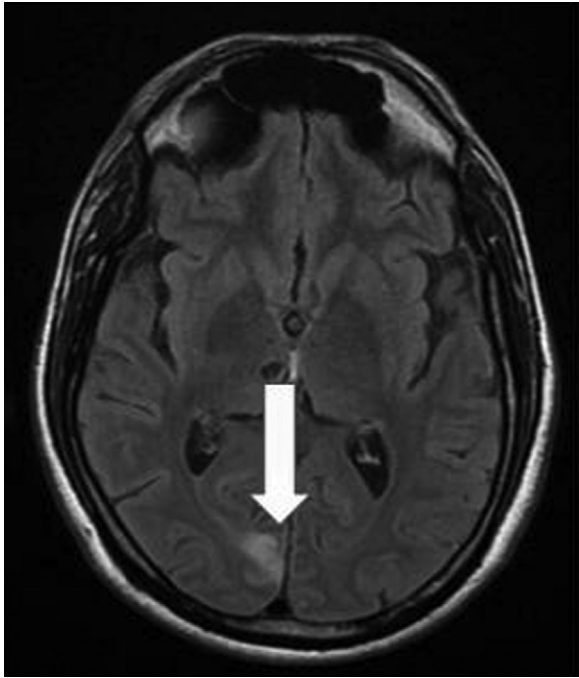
Brain magnetic resonance imaging axial fluid attenuated inversion recovery image showing right occipital gliosis (white arrow)
